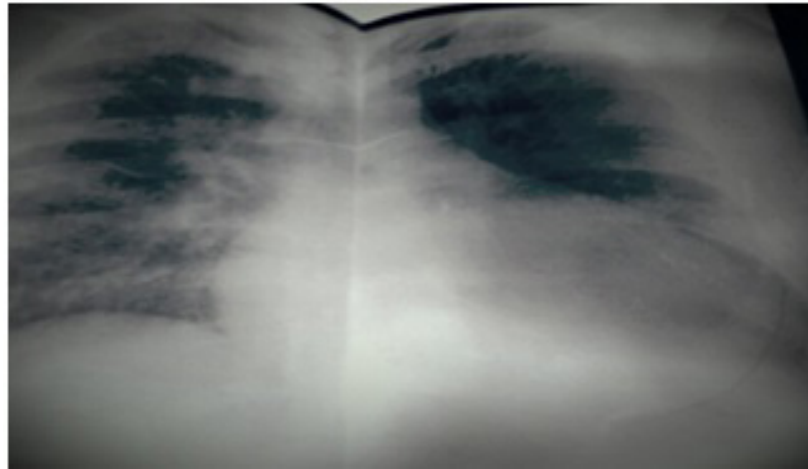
Posterior Anterior chest X-ray: Cardiomegaly 3/4+.
